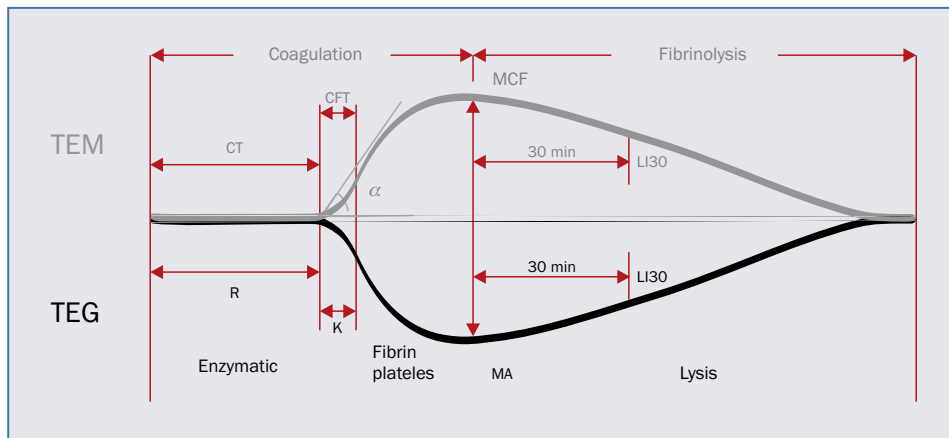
Comparative analysis of thromboelastography (TEG) and thromboelastometry [TEM and rotational thromboelastometry (ROTEM)] tracing and accompanying parameters; CT (clotting time) – period from start of analysis until start of clot formation (until a 2 mm amplitude occurs); CFT (clot formation time) – period until an amplitude of 20 mm is reached (represents clot formation dynamics); MCF (maximum clot firmness) – maximum amplitude of TEMogram; R-time (reaction time) – time to initial fibrin formation; K-time (kinetics time) – time to clot formation; α (alpha angle) – rate of clot formation; MA (maximum amplitude) – absolute clot strength; LI30 (LY30) – fibrinolytic activity 30 minutes after maximum amplitude
